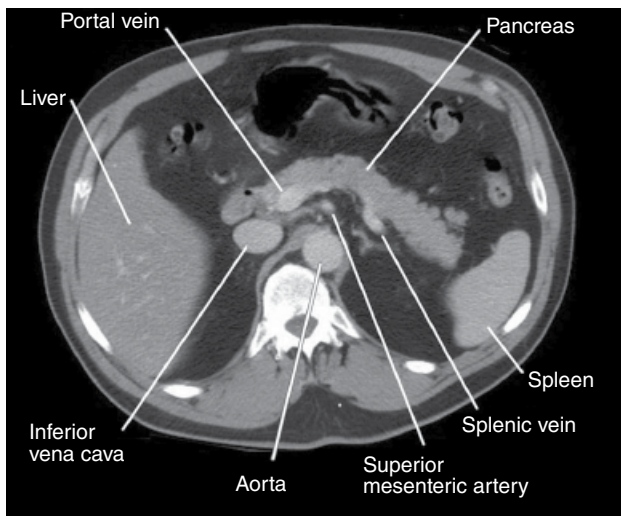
Axial CT scan of the upper abdomen at the level of the pancreas. This scan is oriented with the abdominal wall at the top and the spine and muscles of the back at the bottom as viewed from below. Key structures are labeled. *Source:* Image provided by Jason Ferreira.
